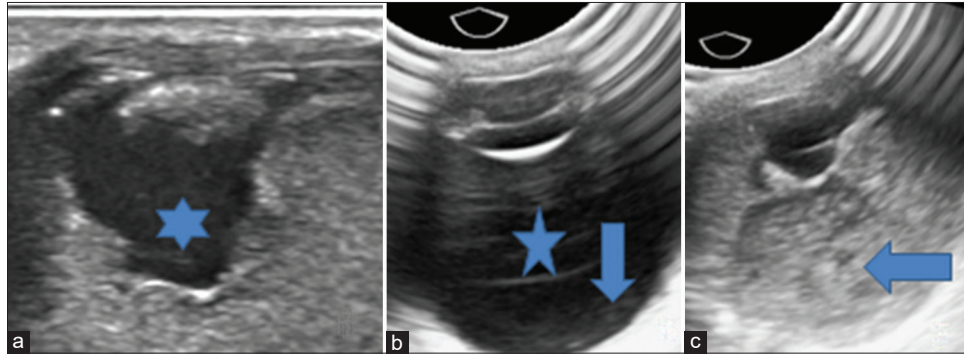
Ultrasound gray scale images. (a) High-frequency linear probe image shows anterior aspect of posterior chamber with undulating vitreous membrane behind the lens (star). (b) Transvaginal sector (TVS) high-frequency probe image shows normal fovea without any retinal detachment (inverted arrow). Vitreous is not showing echoes because of different gain setting (star). (c) TVS image shows the echogenic area within vitreous humor with detached margins (horizontal arrow)
